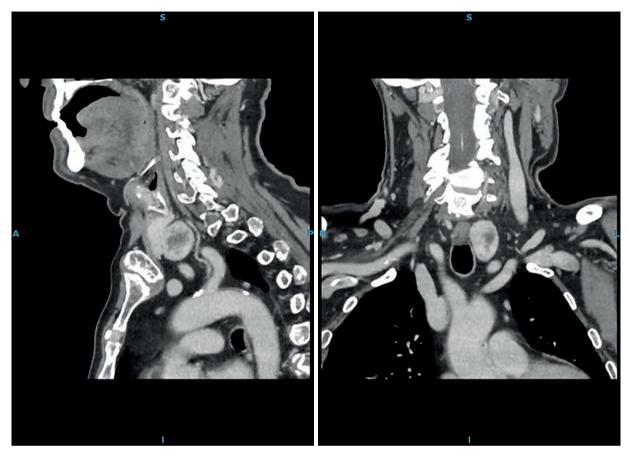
Sagittal and coronal CT images of the paratracheal mass.
